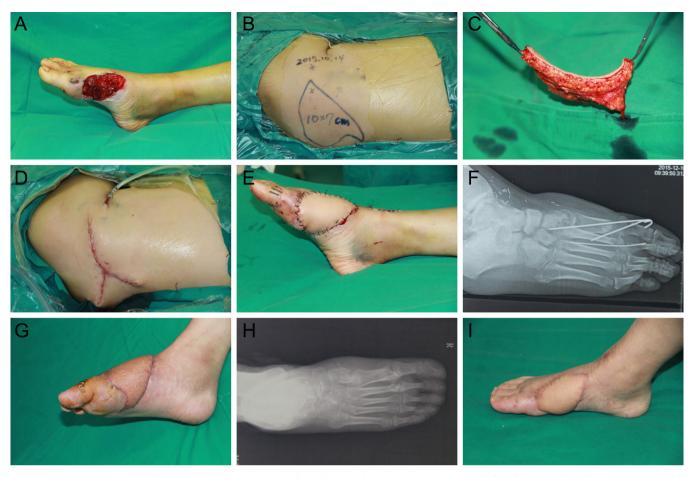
A 28-year-old female presented with a soft defect of the 1/2 foot due to a crash injury. (A) Soft tissue defect after debridement. (B) The designed CSAP flap of the donor site. (C) A free CSAP flap was harvested. (D, E) The donor and recipient regions were closed directly after the operation. (F, G) X-ray and appearance of the recipient area about 2 months after surgery. (H, I) X-ray and appearance of the recipient area about 6 months after surgery.
